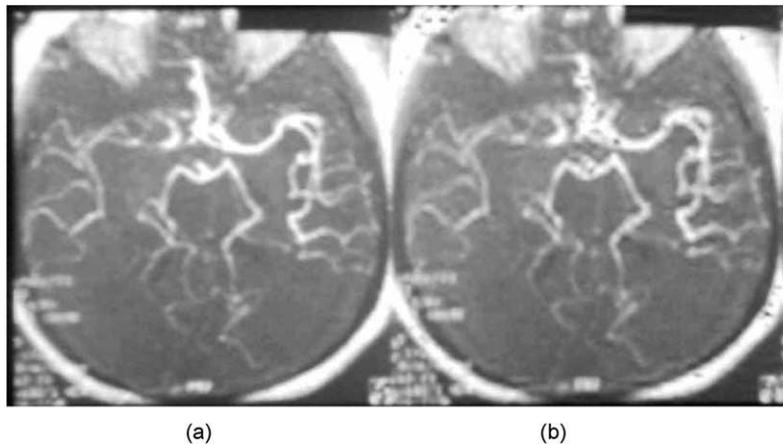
Result of interleaving text in the MRI image: (a) original image; (b) interleaved image.
